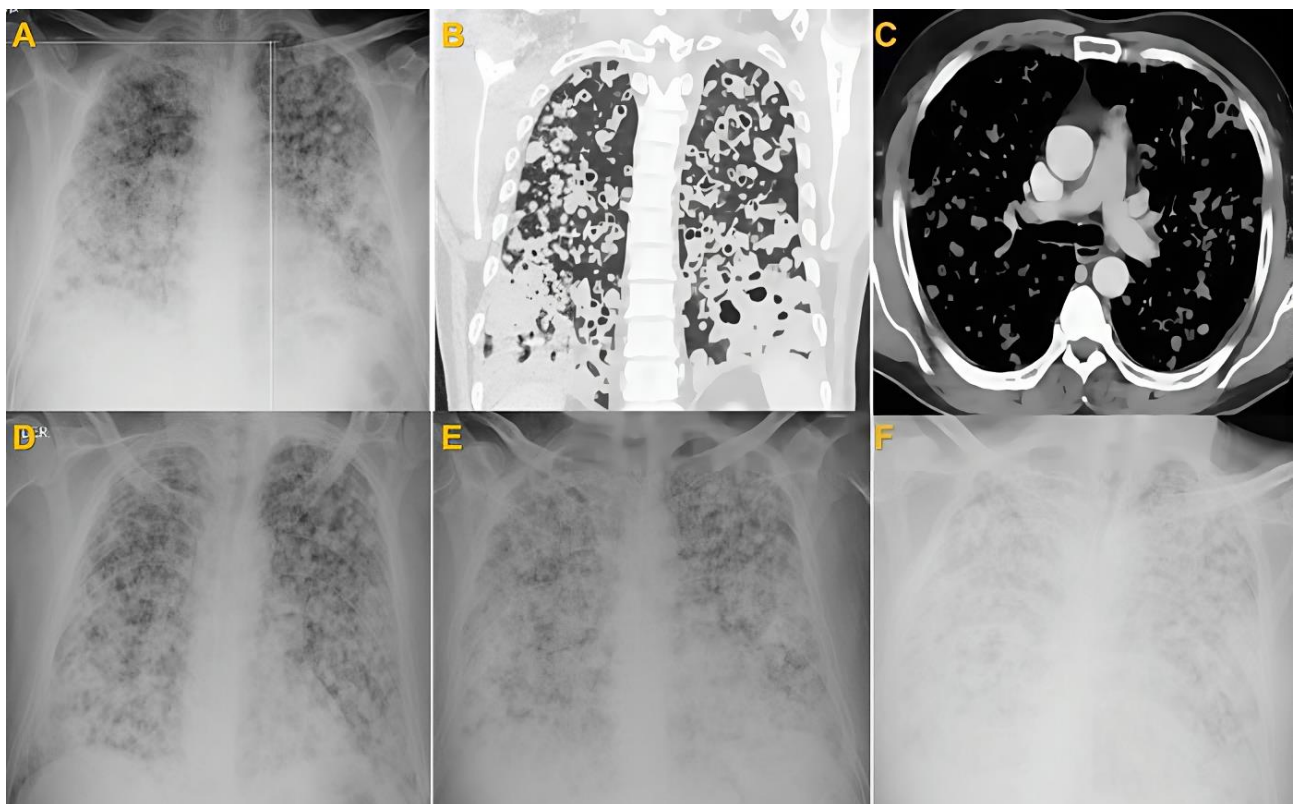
Follow-up of radiological alterations of patient with cavitated nodules & IMA: (A) Emergency admission (X-ray); (B & C). Hospitalization in pulmonology, day 2 TEM chest c/c; (D) Post first flexible bronchoscopy (X-ray); (E) Post second flexible bronchoscopy (X-ray); & (F) Day of death (Source: Own creation © Madaleine López-Hinostroza)
